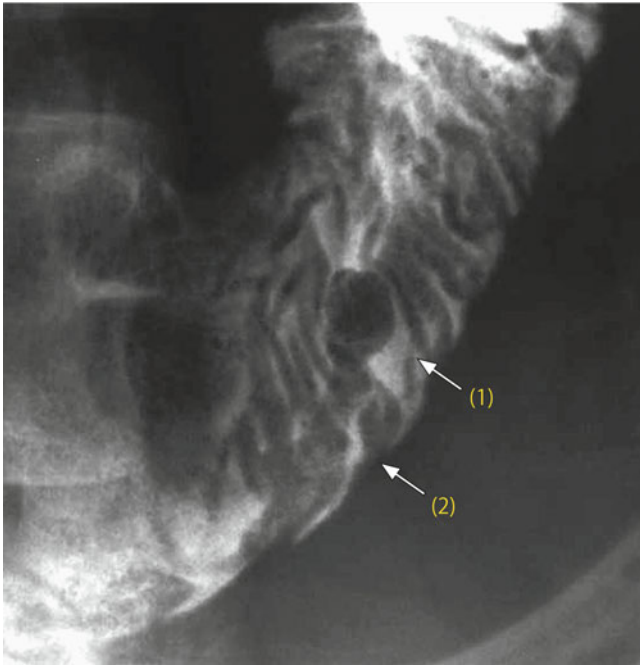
Radiography of the polyp showed a nodular peak (*arrow 1*) and a long peduncle (*arrow 2*)
